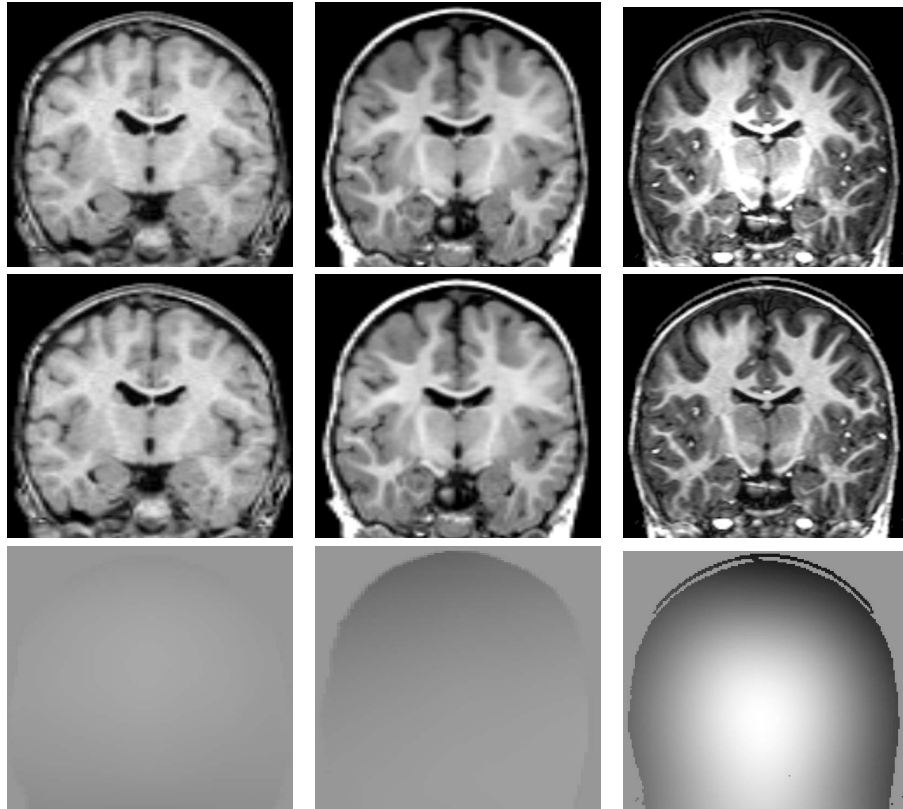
T_1 -W MRI scanned at different magnetic field strengths: (a) 0.5T with virtually no bias; (b) 1T with slightly visible bias; (c) 3T with strong bias. First row: original image; second row: corrected image; third row: bias field. From [Murgasova, 2008].
